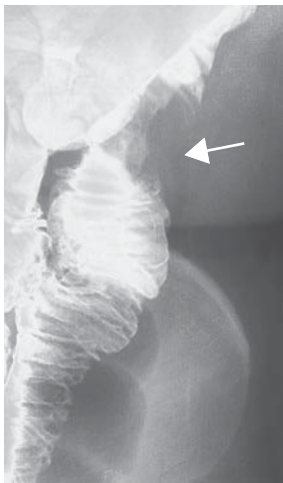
Small bowel enema x-ray demonstrates the jejunal carcinoma ("apple core"). See arrow.
